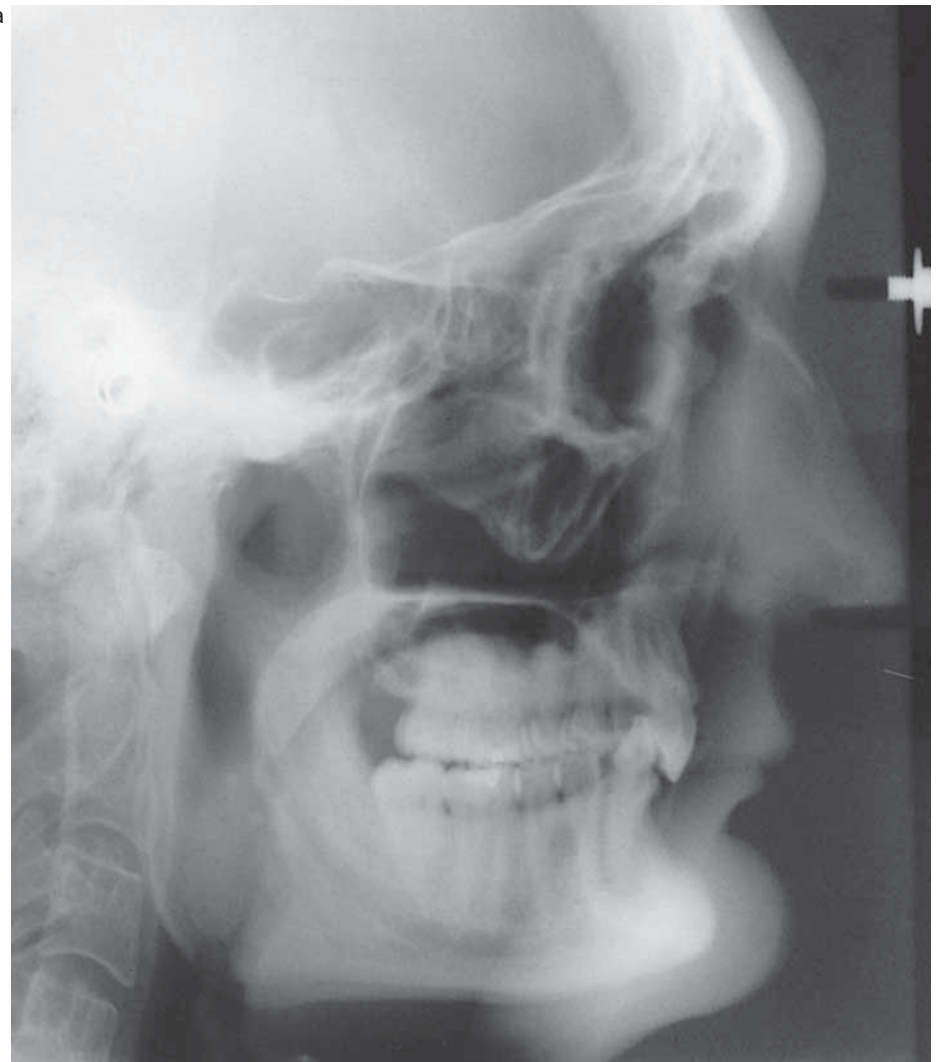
(a) Lateral cephalometric radiograph of a patient with a forward growth rotation of the mandible. (b) Bjork's seven structural signs indicating a forward mandibular growth rotation. Refer to numbered list in text.
